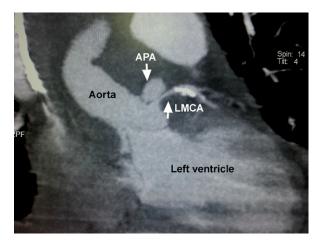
Two-dimensional computed tomogram shows the aortic pseudoaneurysm (APA) originating from the proximal edge of the coronary ostial button and extending through the left main coronary artery (LMCA), causing critical obstruction (the white mass in the LMCA is calcification).
